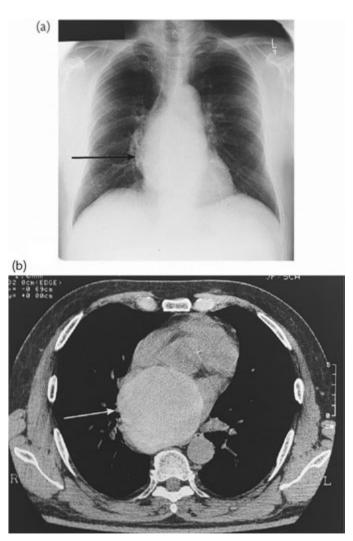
Chest radiograph (a) and CT scan (b) showing a large mass in the mediastinum (arrows) due to a bronchogenic cyst that had been present for 20 years. It was removed when compression of the oesophagus resulted in dysphagia.
